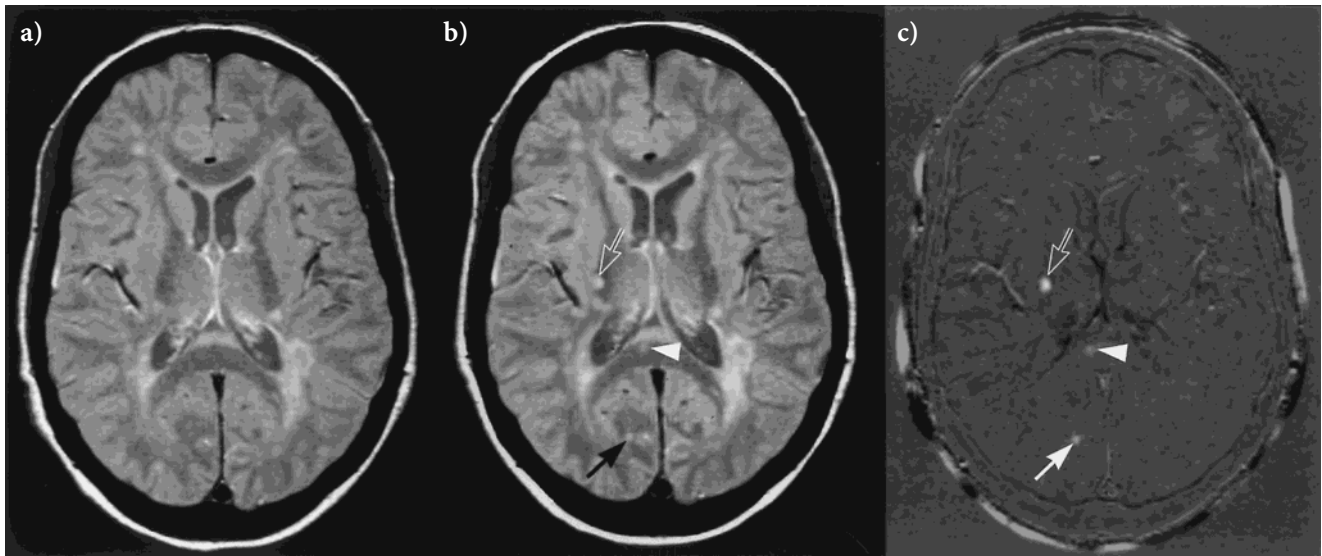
Axial original baseline and registered follow-up proton density weighted MR images with subtracted image of the brain of another MS patient from category V at the level of the lateral ventricles. At least 10 lesions can be seen on the registered image (B). Compared to baseline (A), the bright new lesion in the right capsula interna (open arrow in B and C) and in the right occipital lobe (arrow in B and C) can be easily appreciated on the subtracted image and were both classified as new lesions by all six observers. In C, the new lesion in the splenium of the corpus callosum (arrowhead in B and C) is less bright and therefore less conspicuous on both the follow-up and subtracted image. It was considered new by four observers but ignored by two.
